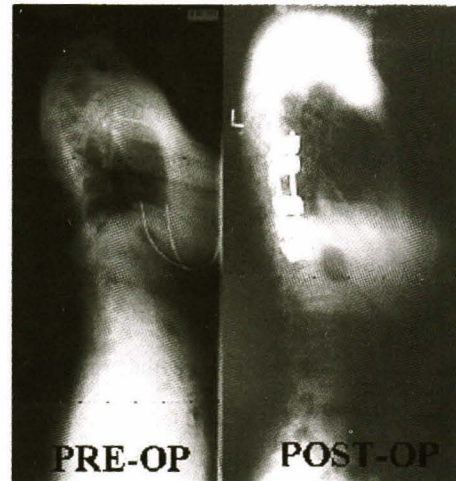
Radiographic demonstration of the sagittal plane alignment restoration in the same patient in Figure 7. The sagittal plane balance has been restored in addition to the coronal plane correction.
